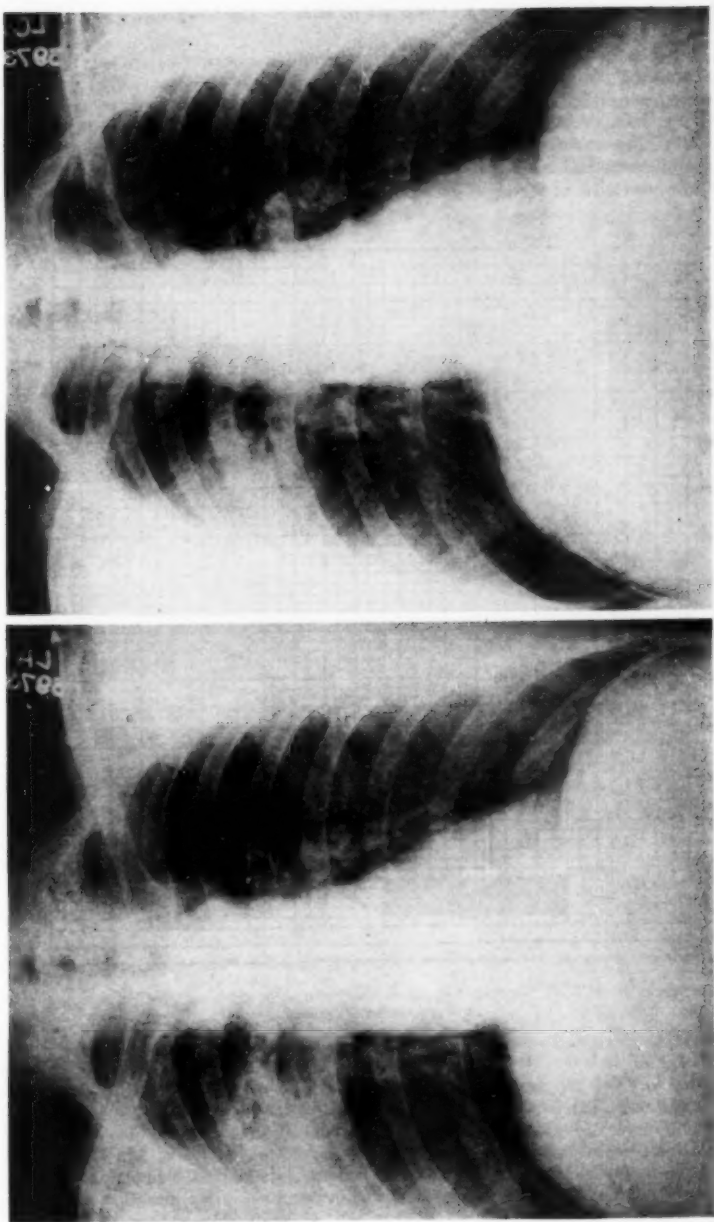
(left), Case 3, Admission chest roentgenogram. Bilateral, patchy infiltration most marked in mid lung field on right.
